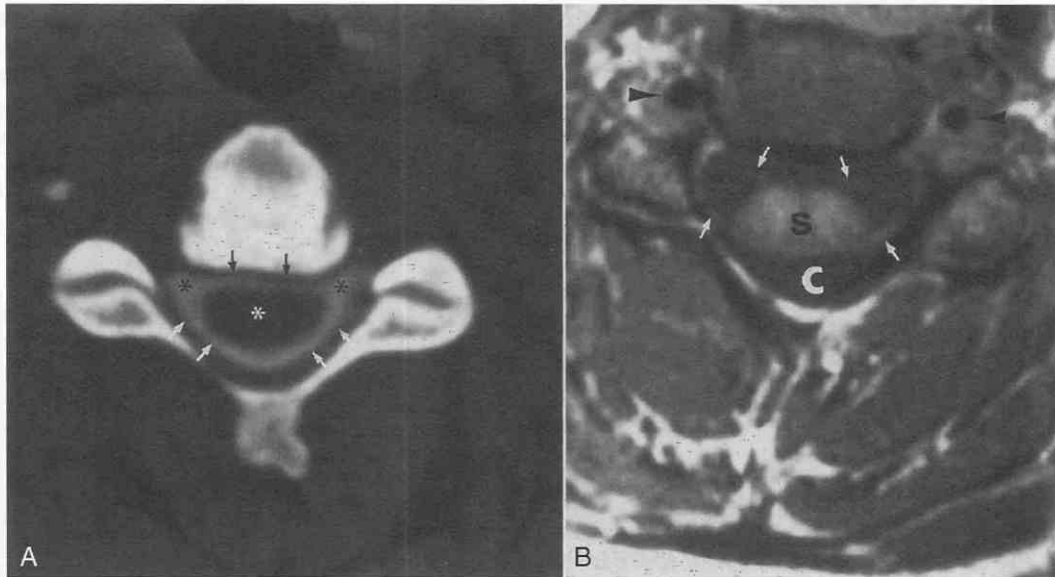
Cervical images. *A*, Cervical postmyelogram CT scan. Note the triangular configuration of the spinal canal (arrows) and oval shape of the spinal cord (white asterisk). The nerve root sheaths (black asterisk) can be seen exiting through the neural foramina. *B*, Axial cervical T1-weighted MR image. c, spinal canal; s, spinal cord. Arrows indicate nerve roots; arrowheads indicate vertebral arteries in the transverse foramina.
